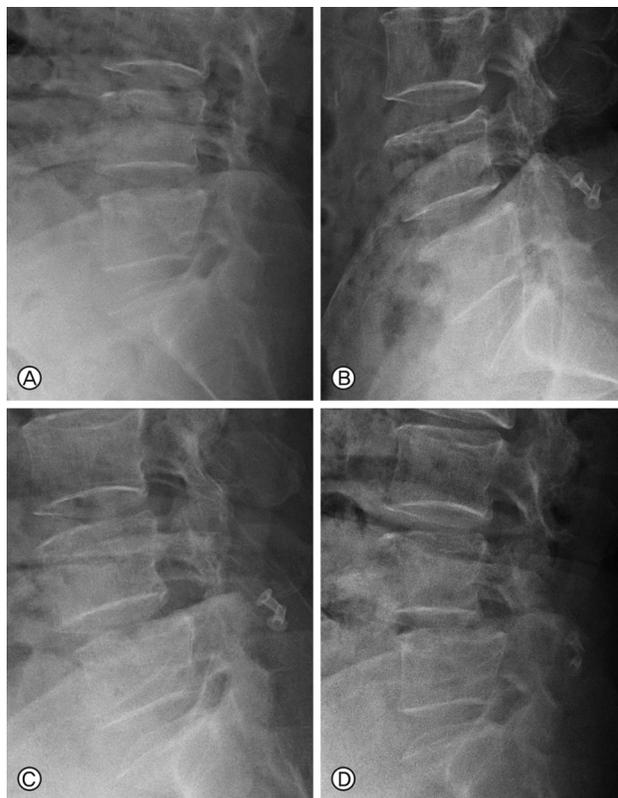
Lateral radiographs showing increasing flexion instability and spondylolisthesis. A: preoperative radiograph. B: postoperative radiograph one month after surgery, C: six-month follow-up, D: 12-month follow-up.
